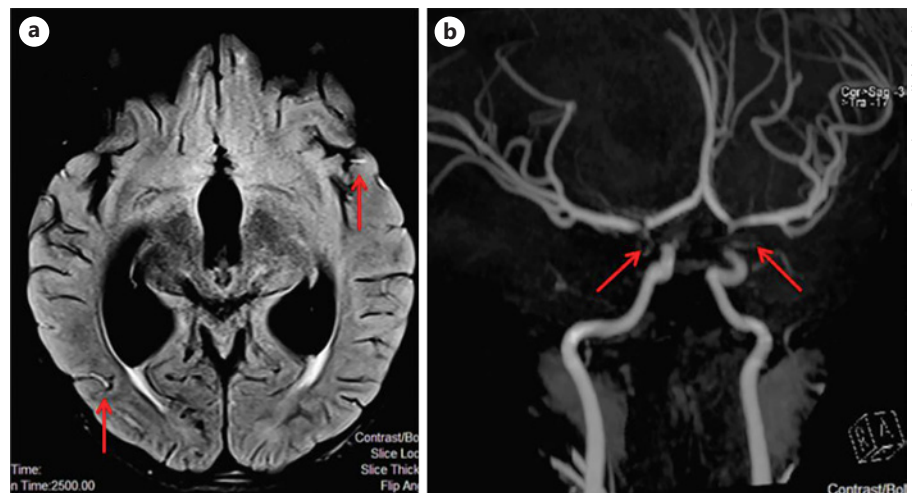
FLAIR sequence showing bright intravascular signal intensity consistent with slow flow in both MCA branches (Red arrows) (a); 3D TOF MRA images showing bilateral narrowing of the ICA supraclinoid segments and proximal parts of A1 and M1 segments (Red arrows) (b). MCA, middle cerebral artery; TOF, time-of-flight; MRA, MR angiographic.
